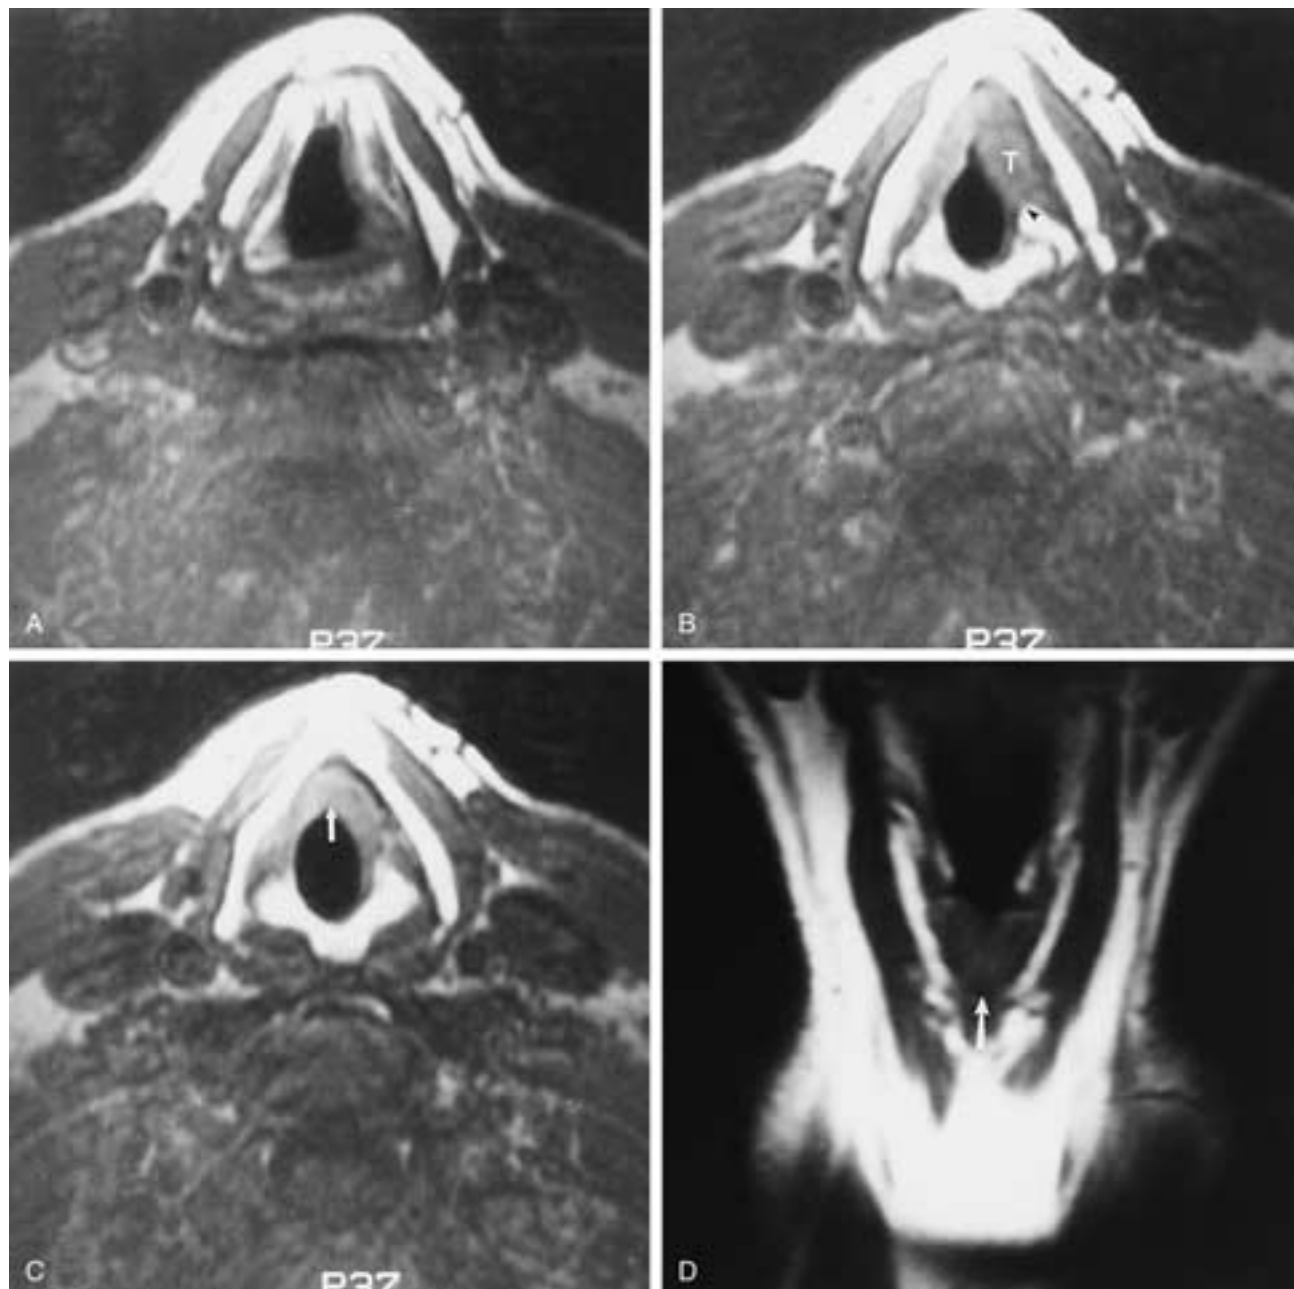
True cord lesion, 1.5 Tesla, MR image. A, Level of the false cord is relatively normal. Axial T1-weighted image. B, Tumor (*T*) at the level of the true cord. *Arrowhead*, vocal process. C, Level of the lower true cord. The tumor crosses the midline (*arrow*). D, Coronal image shows increased tissue (*arrow*) beneath the anterior commissure.
